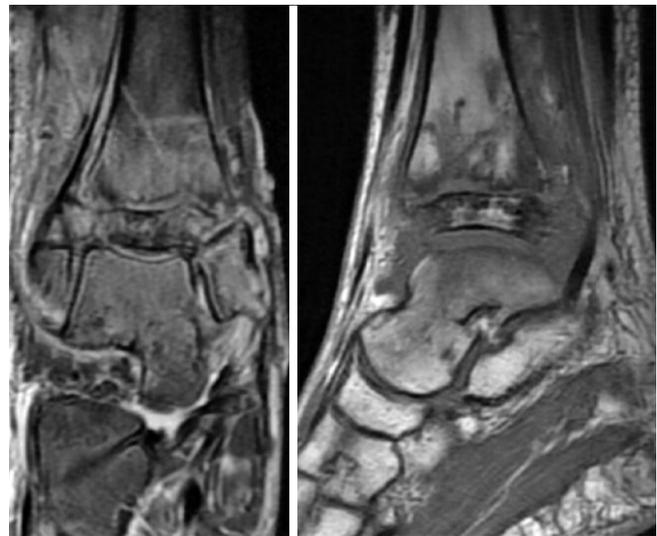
Right ankle MRI concerning for osteomyelitis upon initial presentation to our medical center.
